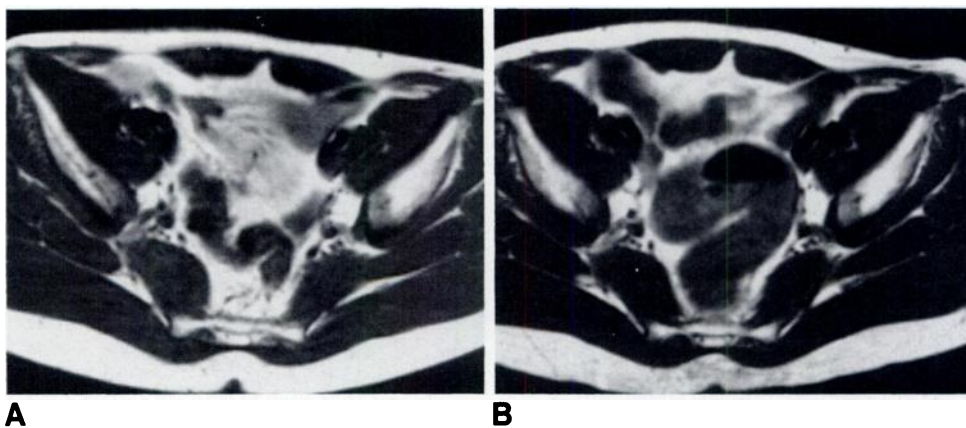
Axial T1-weighted MR images of sigmoid colon.
